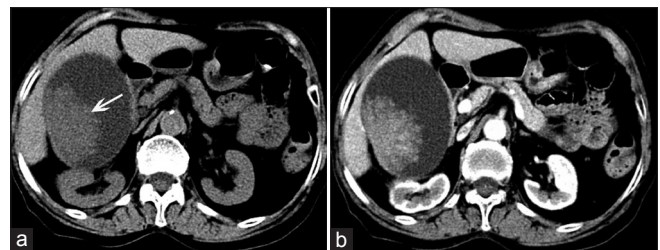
CT shows cauliflower-like broad-based lesions in the gallbladder. The mass is of intermediate density (about 31–36 HU) on non-enhanced CT (arrow) (a), with strong enhancement on contrast-enhanced CT (b)
